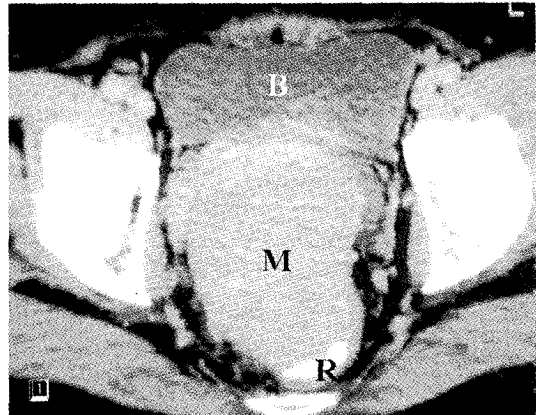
CT scan showing a mass in the prostate (M) between the bladder (B) and the rectum (R)
